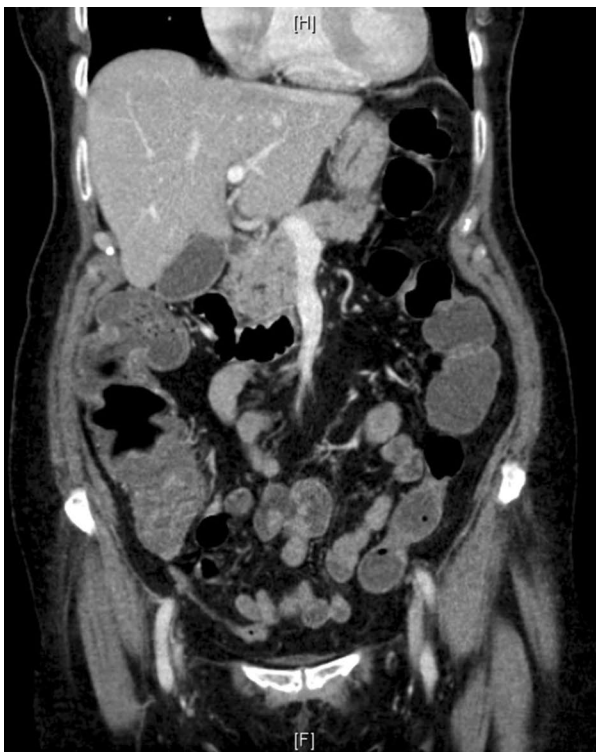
CT scan of the abdomen revealed mucosal thickening and enhancement involving the rectosigmoid colon, as well as the cecum
